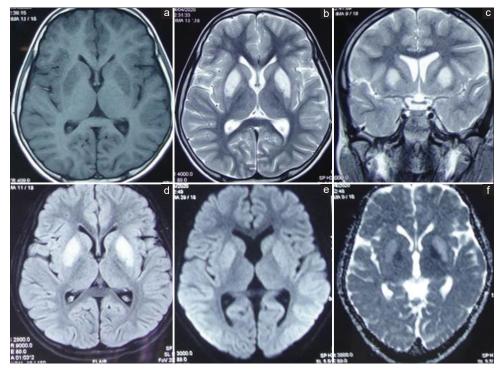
Brain magnetic resonance imaging revealed bilateral caudate nucleus and putamen iso-hyperintense on T1 weighted image (a), hyperintense caudate and putamen with putaminal swelling in T2 and Flair images (b, c and d) and no diffusion restriction (e and f)
